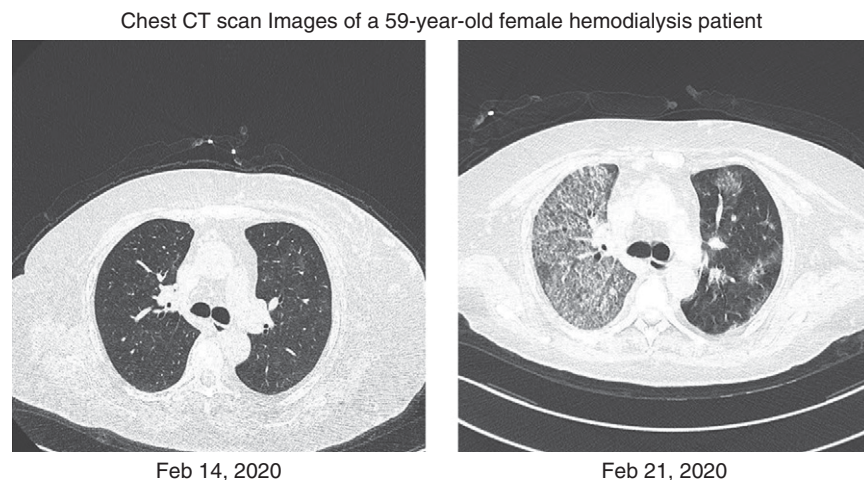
Chest CT scan images of a patient on hemodialysis infected with severe acute respiratory syndrome coronavirus 2. There were no obvious abnormal radiologic findings on admission. Extensive ground-glass opacities can be seen in right lung after 7 days. The patient was dead.
